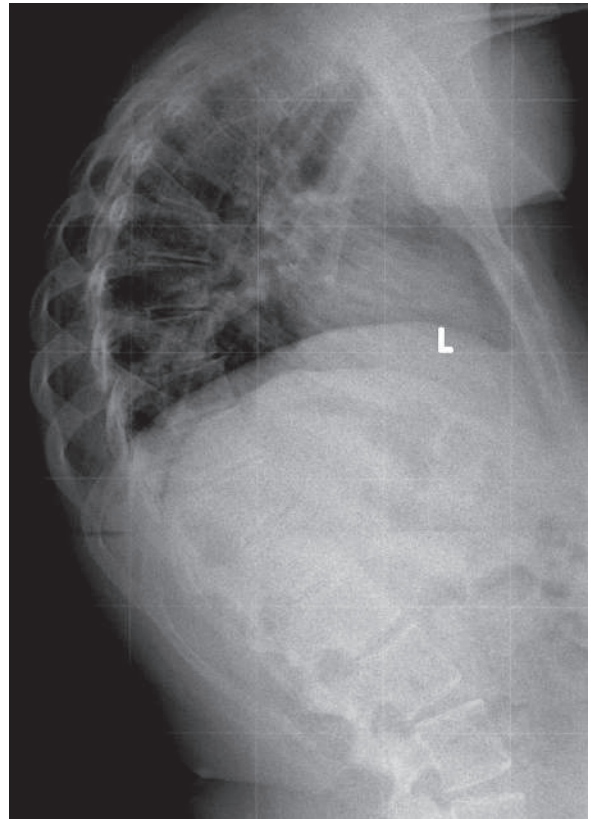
Lateral plain radiograph of the thoracic spine of an 18-year-old girl with SD shows marked thoracic kyphosis with wedging of more than three adjacent vertebrae
